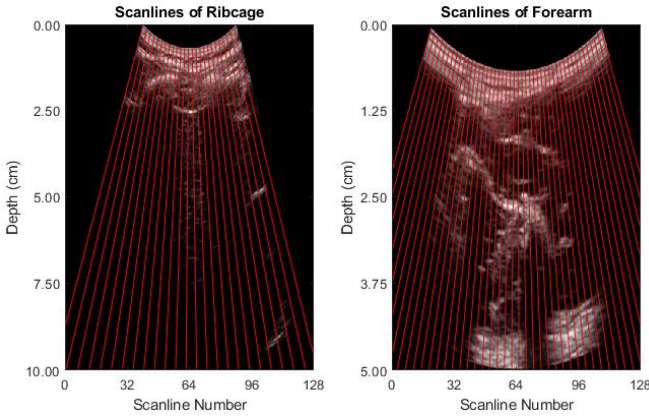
Creating the scanline paths on a curvilinear ultrasound image of the right ribcage and the forearm with different depth settings on the curvilinear transducers. Two initial paths are creating by computing the slopes of the two lateral edges, which are detected by tracking the ring-down artefact. The remaining paths are creating by linearly interpolating the slope of pixels in between the lateral edges.
